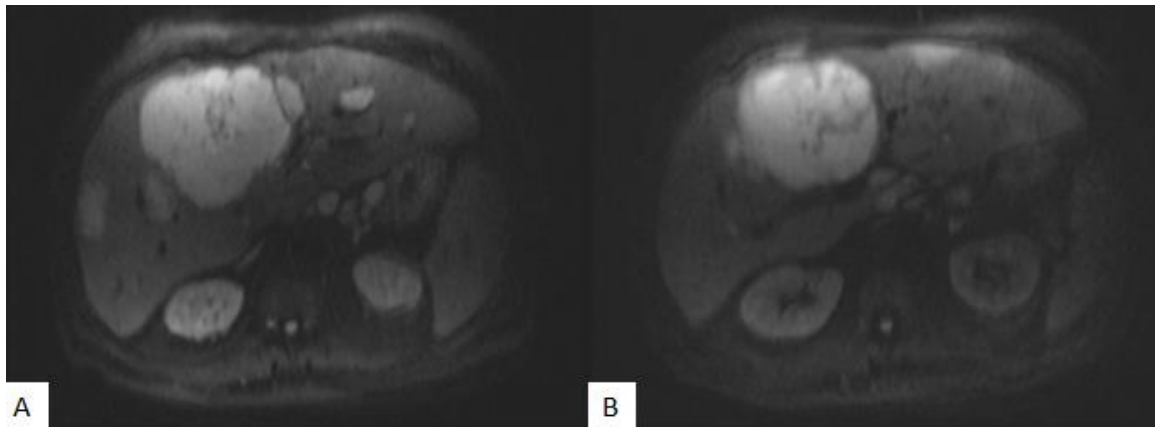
Liver MRI in diffusion sequences B400 (A) and B800 showing restriction of the mass
